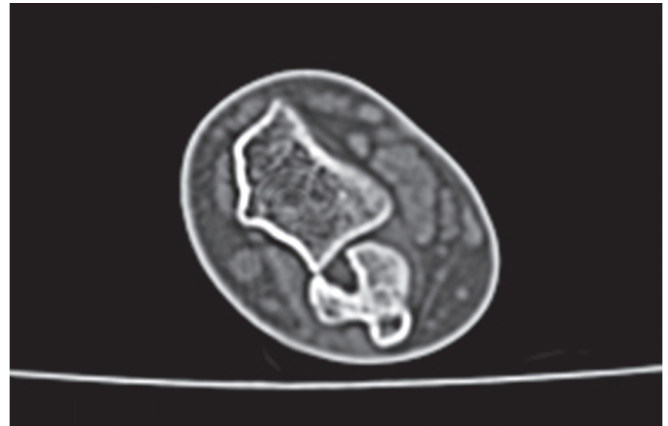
Computed tomography scan showing malunited intra-articular fracture of ulnar head, which mechanically blocked the radius in supination
